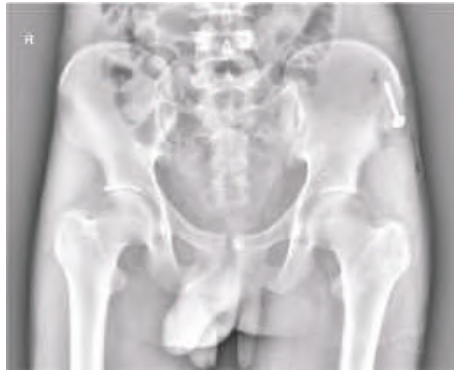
Post-operative pelvis with both hips x-ray showing anatomical reduction of fracture and implant in situ.
